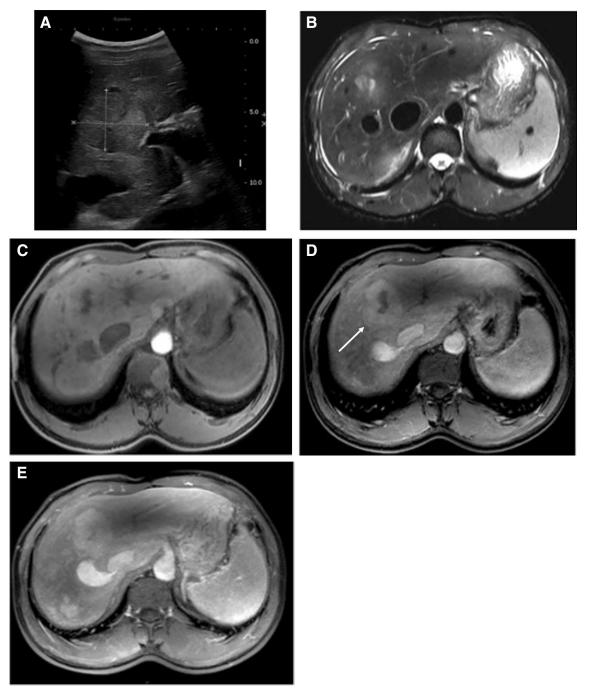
A 22-year-old female with congenital portosystemic shunt and a FNH-like lesion (arrow). A On ultrasound, the lesion is homogeneous and isoechoic to the liver. B, C On T2-weighted and on fat-suppressed T1-weighted MR imaging, the liver lesion is isointense to the liver and contains a central scar that is hyperintense on T2-weighted and hypointense on
